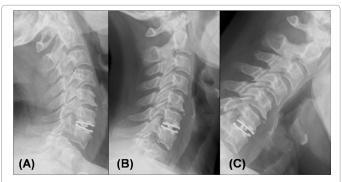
Extension (A), neutral (B) and flexion (C) lateral radiographs 24 months following insertion of Synergy Disc demonstrating 13.9 degrees of ROM from extension to flexion and an upright (B) disc angle of 6.7 degrees of lordosis in neutral.
